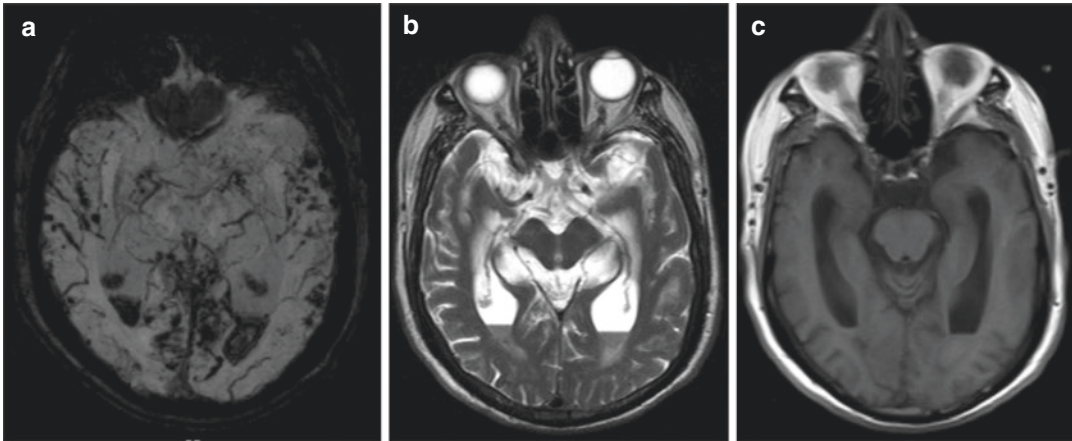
Patient with intraventricular hemorrhage (IVH) and amyloid angiopathy, (a) SWI image demonstrates microbleeds in temporal lobes and IVH as signal loss in temporal horns, (b) T2-weighted image of the same
